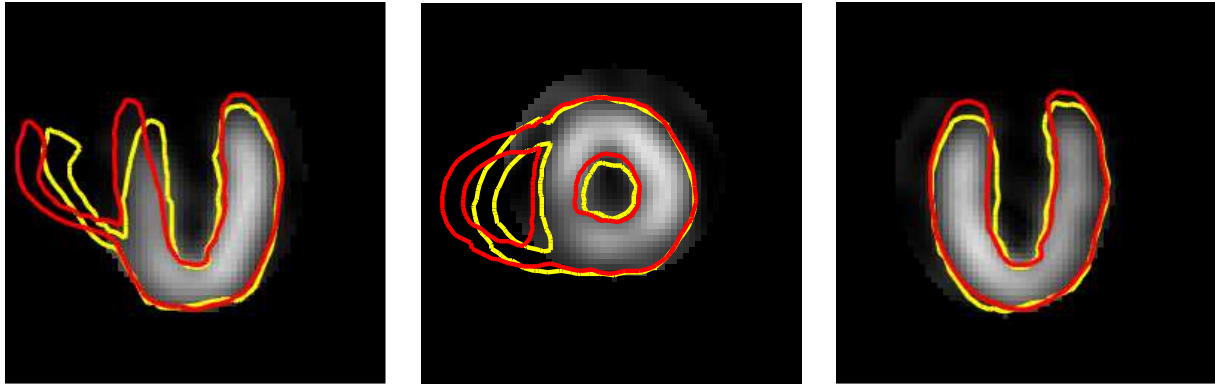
Comparison of the segmentation of a SPECT image sequence, in three orthogonal slices of the tele-systolic position (red: passive biomechanical model, yellow: pro-active model). The electromechanical model stays closer to the image boundary, especially near the base (axial contraction) and we can observe the right ventricle contraction of the model, even if the right ventricle is not visible in the image (due to a previous region of interest extraction).
